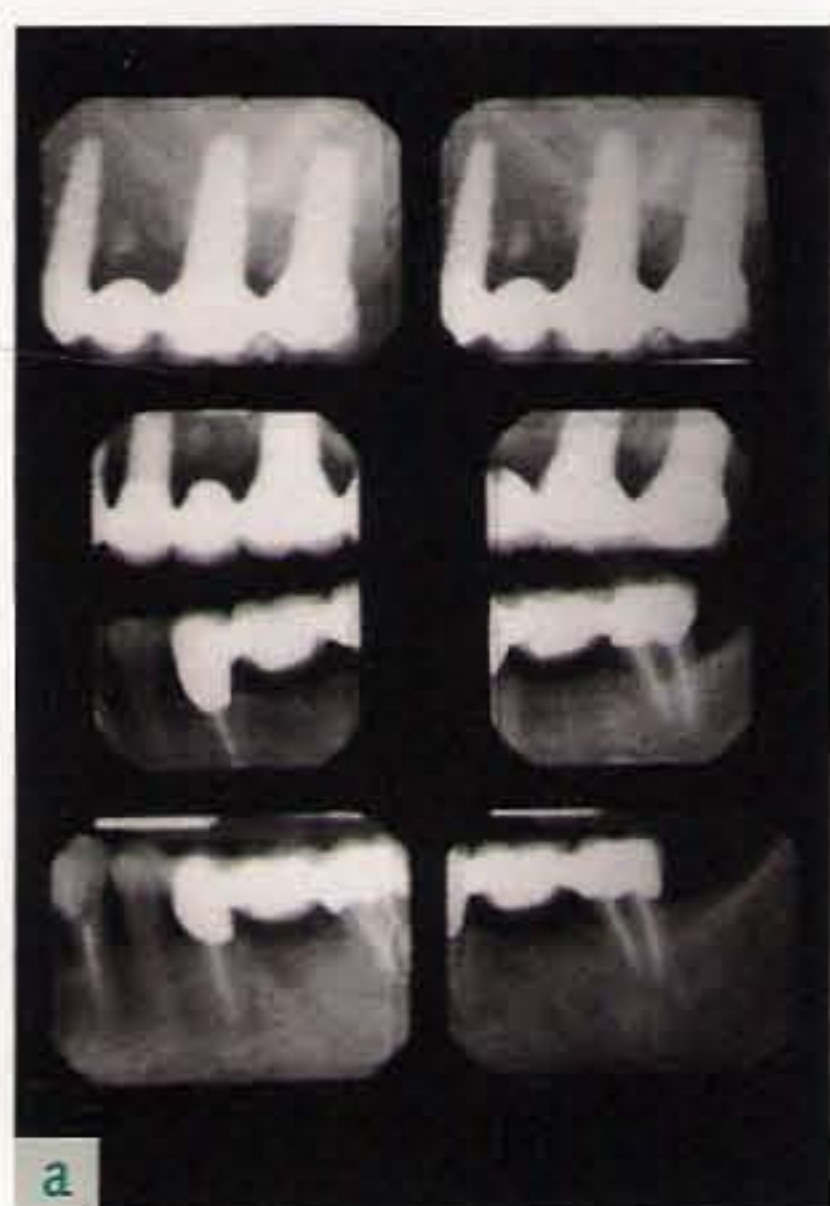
(a to c) Intraoral control radiographs of the final prosthesis.
